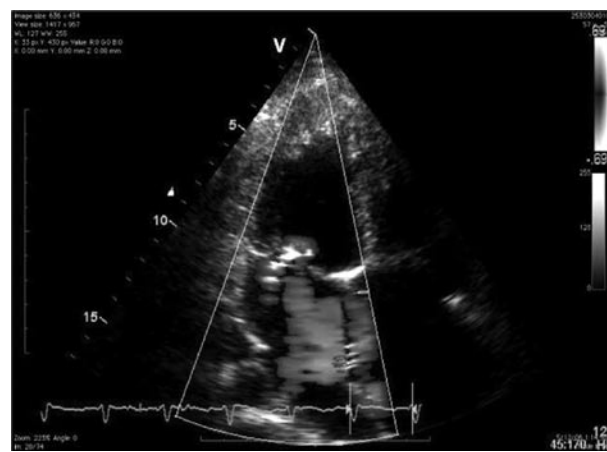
Color Doppler in four chamber view showing the color flow across the ASD and mild mitral valve regurgitation
